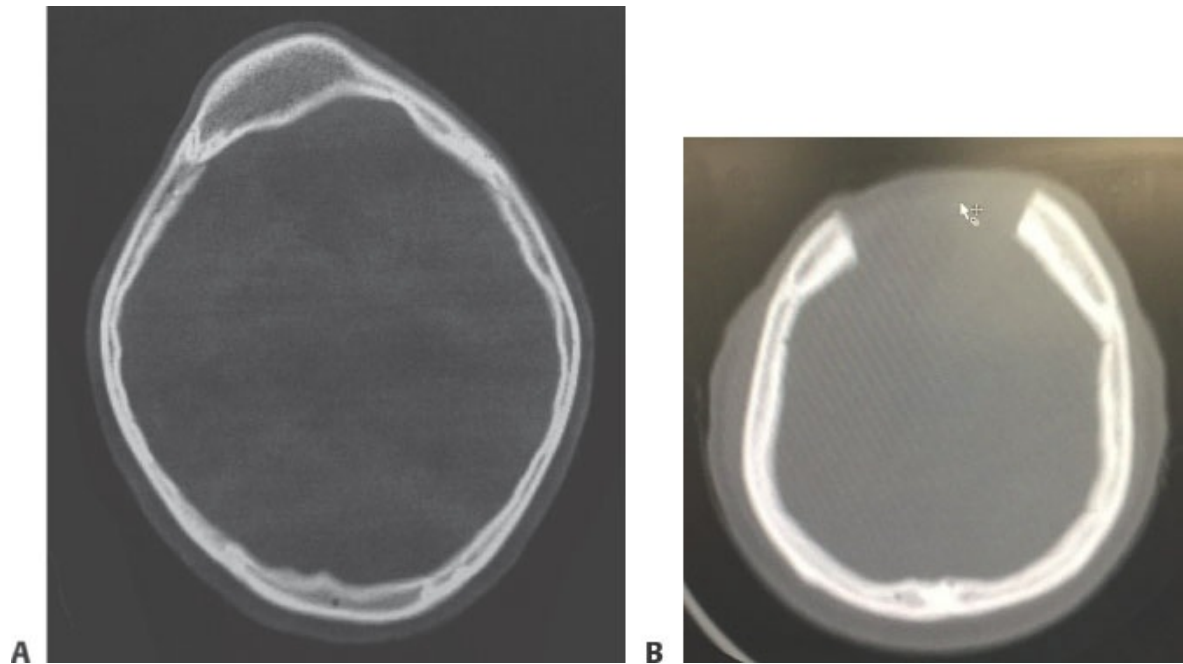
• Preoperative axial CT scans of a tumor (A) and of a left frontal defect (B).
